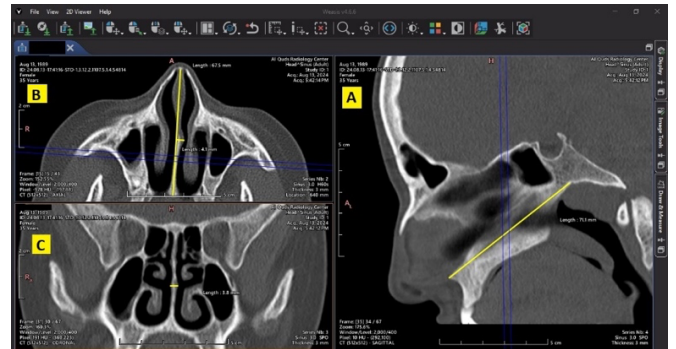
depicts CT scans of the nasal septum with morphometric measurements in three planes: sagittal (A), axial (B), and coronal (C).
